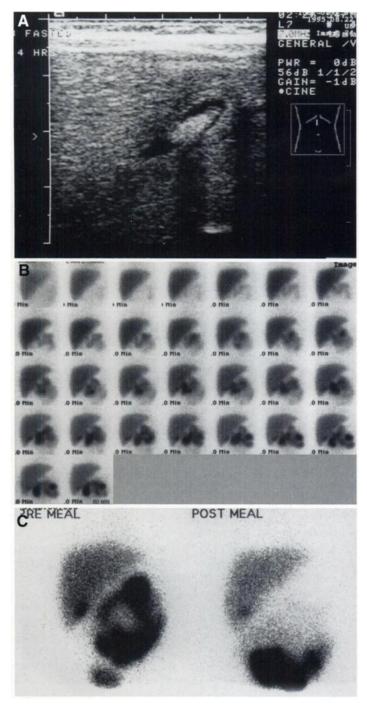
Gallstones. A 3-mo-old female infant presented with jaundice and conjugated hyperbilirubinemia that settled over several days. Ultrasound (A) shows a small gallbladder containing an echogenic stone. The hepatobiliary scan shows good extraction and excretion of tracer with a small functioning gallbladder (B), which contracted after a meal (C). There was no obstruction to bile flow.
